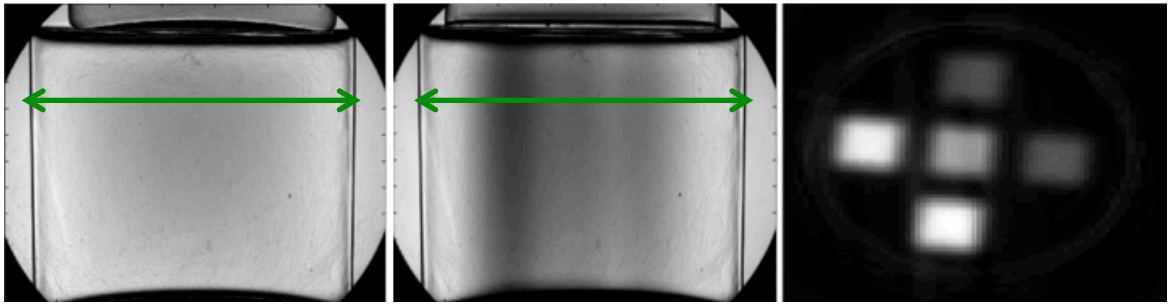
Example of optical-CT projection images pre-irradiation (left), post-irradiation (center) and axial reconstructed slice (right- position in dosimeter shown with solid green arrows).
